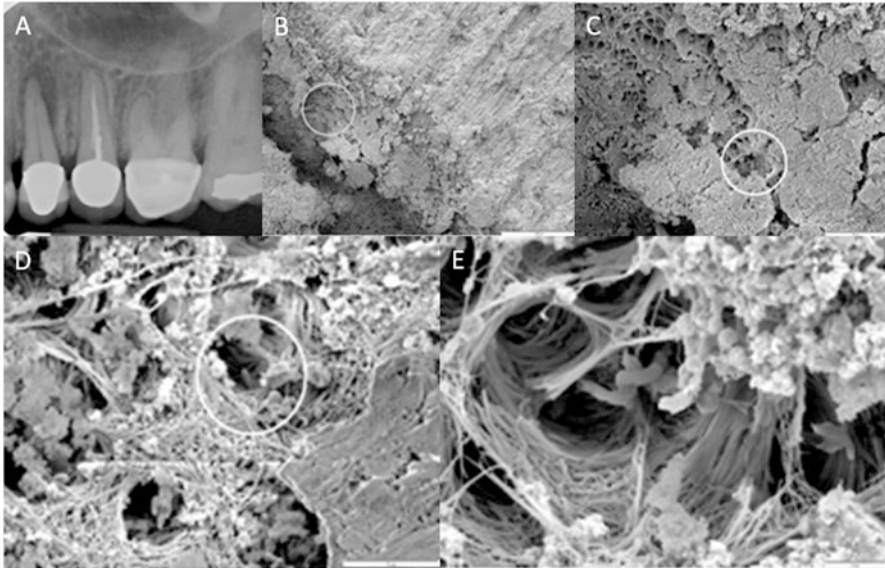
Biofilm within the root canal. (a) Radiograph showing maxillary left first premolar. Crown delivered 3 years previously. Patient presented with intermittent pain, particularly upon chewing, and absence of deep probing. Diagnosis: necrotic pulp and symptomatic apical periodontitis. Patient elected extraction. (b) SEM image of middle section of the root canal wall showing necrotic pulp tissue and debris covering dentinal tubules; (c) Close-up of circled area in (b); (d) Close-up of circled area in (c) showing dentinal collagen fibers and bacteria inside the dentinal tubule; (e) Close-up of circled area in (d) showing bacteria inside dentinal tubule. (Images from David Jaramillo)
